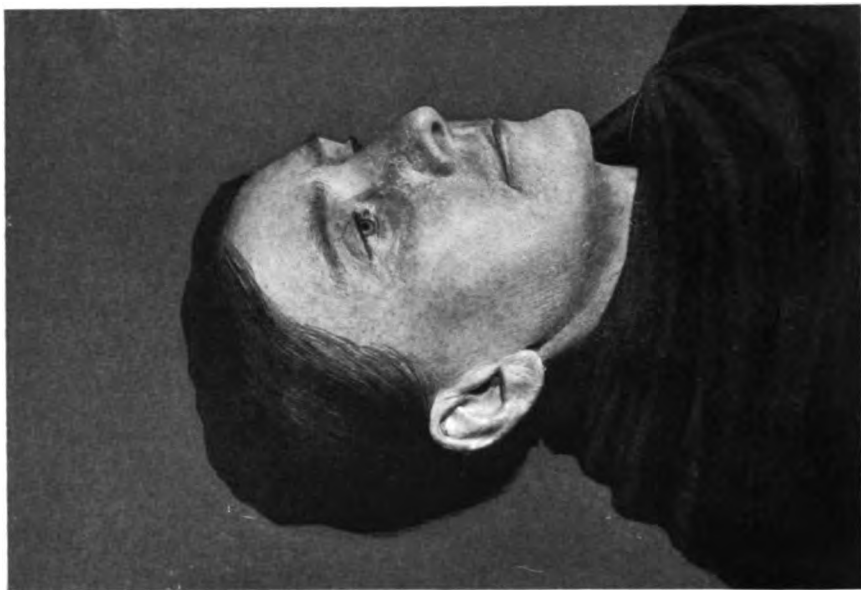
Lupus vulgaris after 8 months' treatment with the x-rays.
